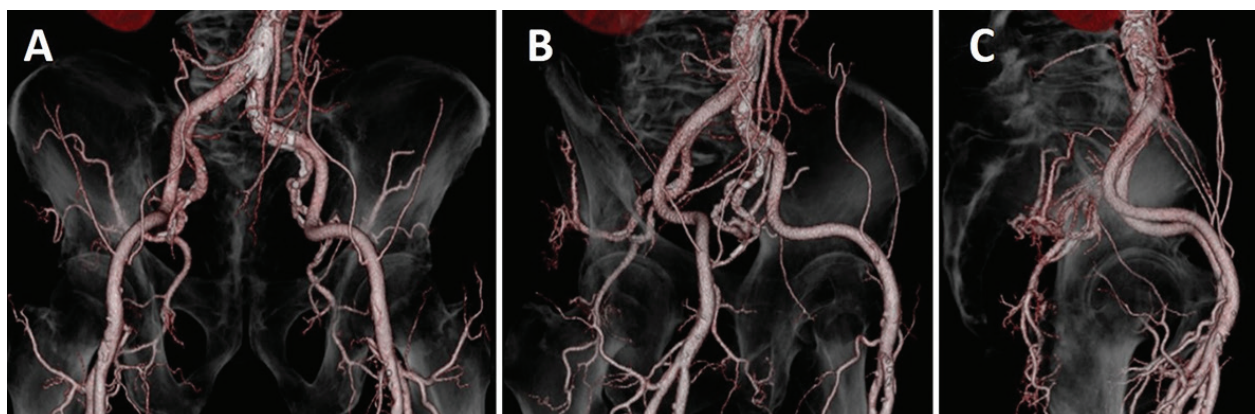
Aortoiliac artery by 3D CT angiography. (A) AP view, (B) RAO 45° view, (C) lateral view. RAO view and lateral view show that aortoiliac arterial system located in intraperitoneal space with three-dimensional CT angiography.
